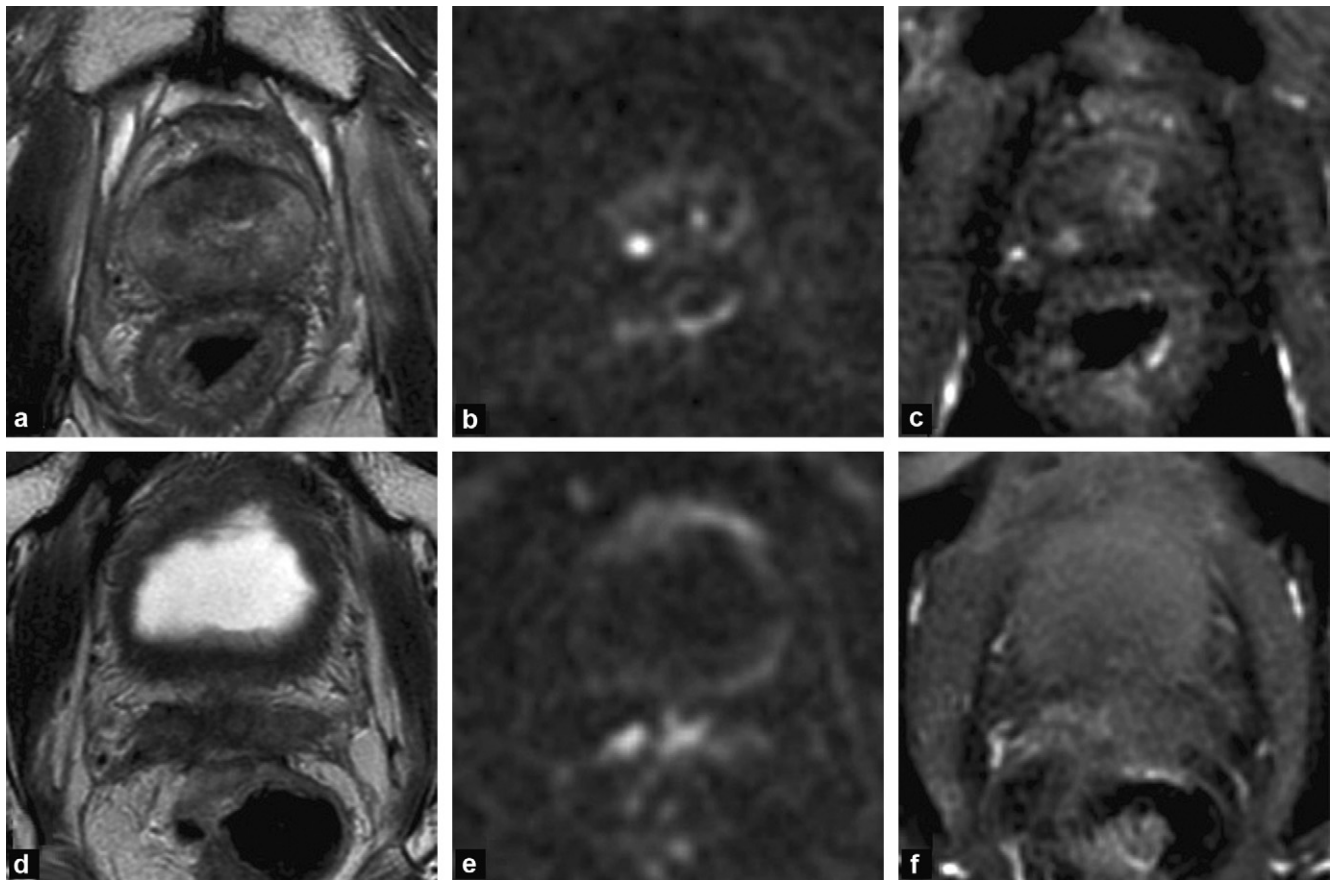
Axial multiparametric magnetic resonance imaging (MRI) of the prostate passing through the middle part the gland (a–c) and through the root of the seminal vesicles (SV) (d–f), T2-weighted (a and d), in diffusion (b = 2000s/mm², b and e) and in T1 after contrast agent injection (dynamic imaging, c and f).
